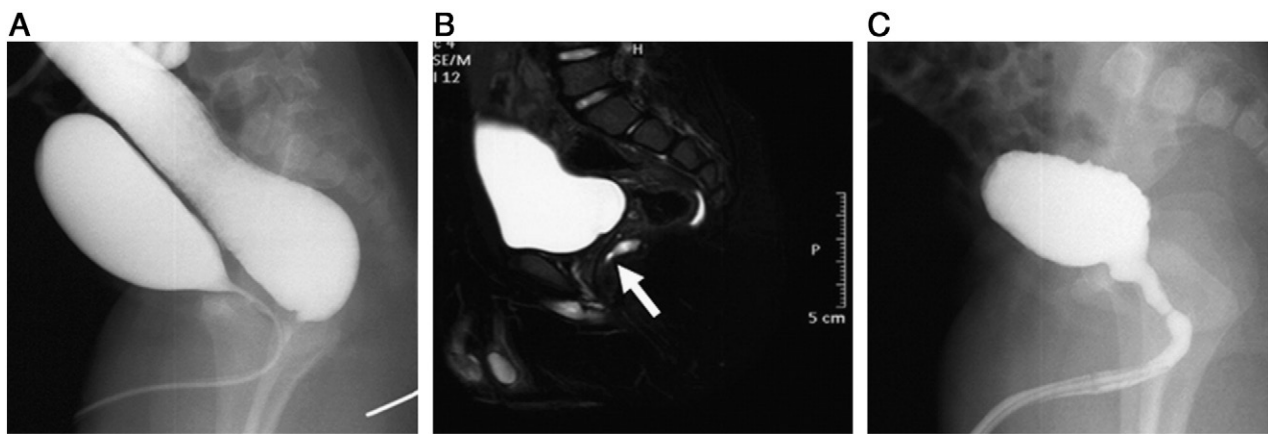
Cystic structure in a case of rectoprostatic urethral fistula after LAARP. A, Preoperative colostogram and urethrogram. B, Postoperative MRI showed a tiny cystic structure from the posterior urethral wall. C, Voiding cystourethrography did not show any cystic structure in the same patient.
